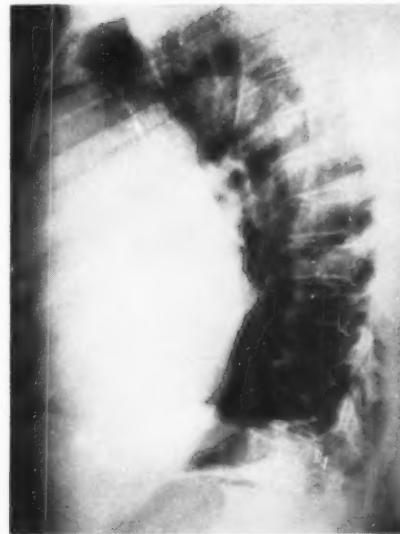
Lateral X-ray showing the mass anteriorly situated.
